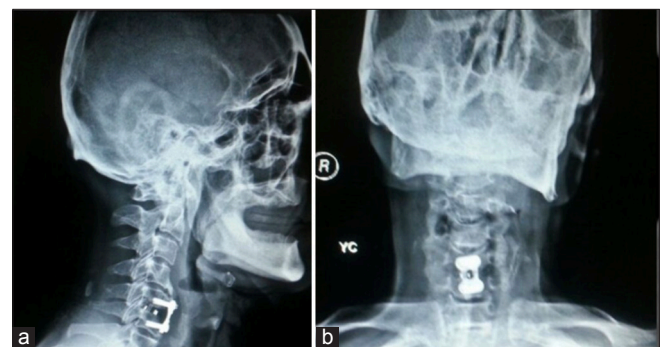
(a) Lateral and (b) anteroposterior X-ray post-ACDF and plate fixation surgery. ACDF: Anterior cervical discectomy and fusion
